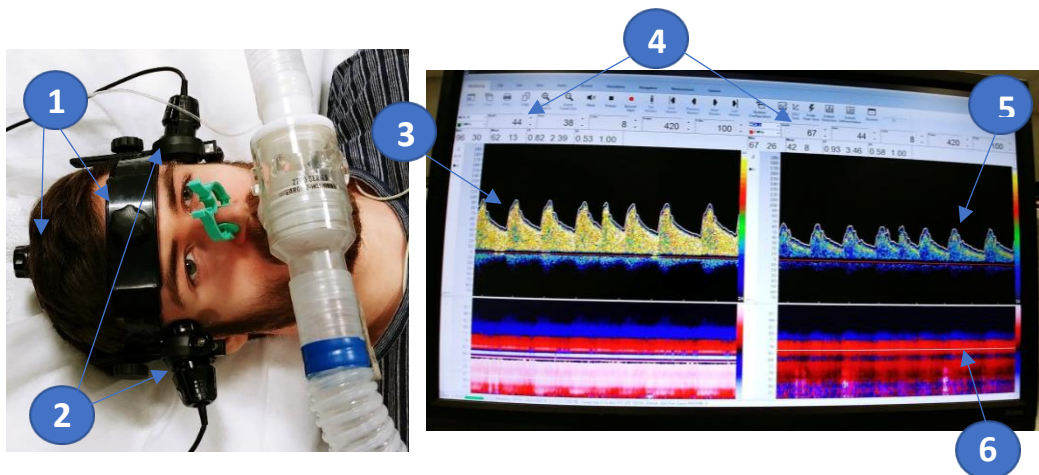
Transcranial Doppler Ultrasound set up and data collection. Equipment and data are displayed as follows; 1) Transcranial Doppler Ultrasound head set, 2) 2MHz Doppler probes with the top recording posterior cerebral artery (PCA) blood flow velocity and the lower recording middle cerebral artery (MCA) blood flow velocity , 3) MCA blood flow velocity, 4) Settings including depth and gain along with mean blood flow velocity data, 5) PCA blood flow velocity, 6) Depth of probes set in accordance with position of the red line indicating artery depth.
